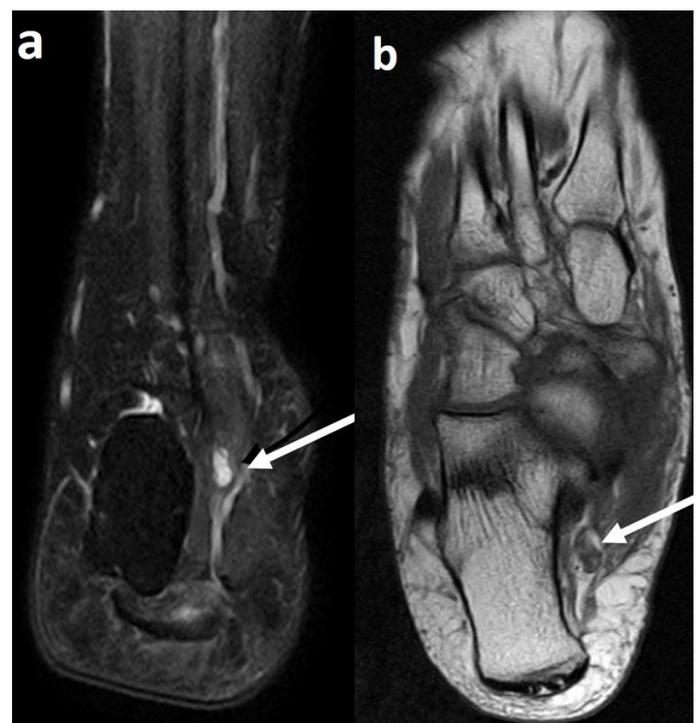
2A. MRI films showing the 'ganglionic cyst' in the tarsal tunnel (↓) between the neurovascular bundle, abutting the nerve along its medial aspect; 2B. showing the tibialis posterior tendinopathy (↓).
